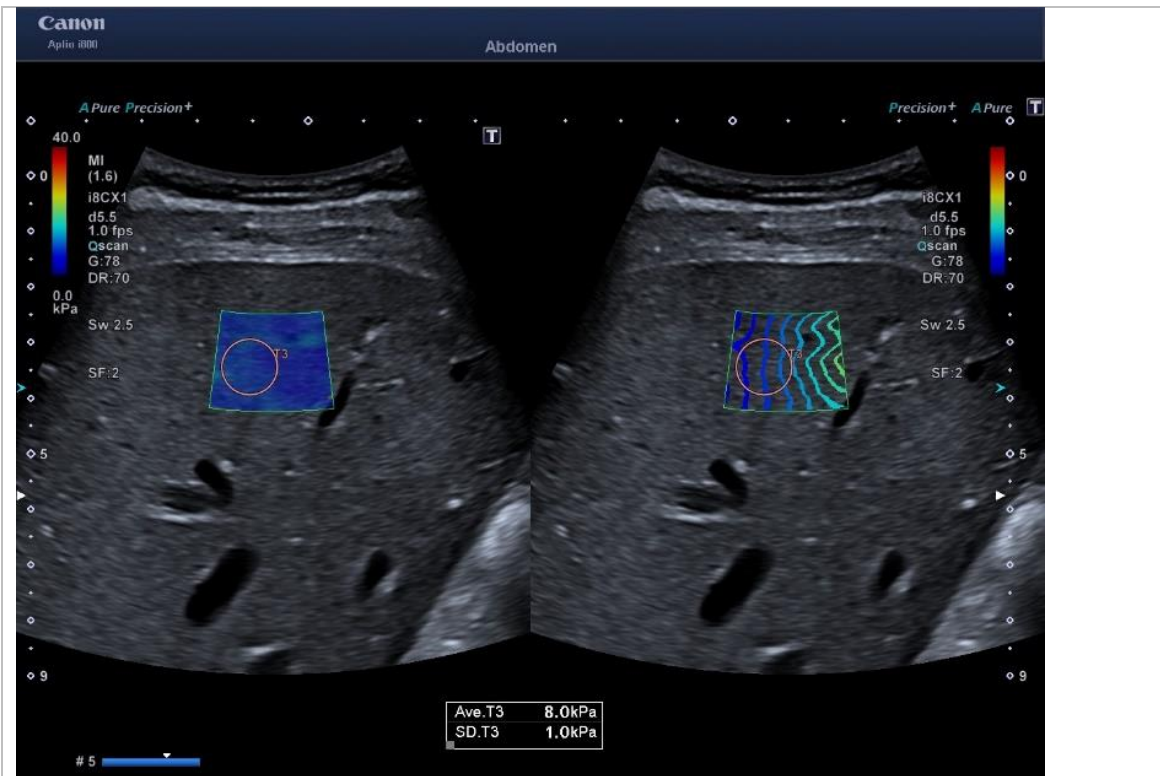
2D-SWE elastography in a patient with CHB with calculation of liver stiffness (LS, kPa) and additional calculation of a steatosis parameter (ATI) as part of the multiparametric ultrasonography of patients with CHB.
